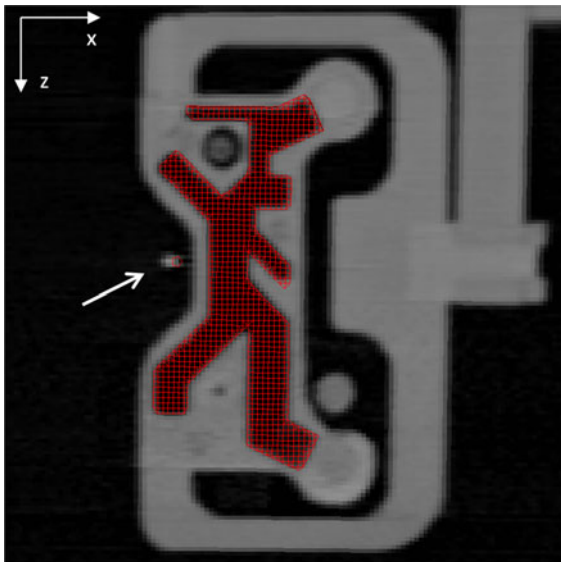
Location of the needle (marked by arrow) with respect to the upper fiducial in a CT image. The registered fiducial model is overlaid in red with the registered needle location shown as a faint circle beside the white spot of the actual needle in the image. Note the misalignment in the *x*-direction of the visible white needle compared to the registered red needle, as explained in the text.
